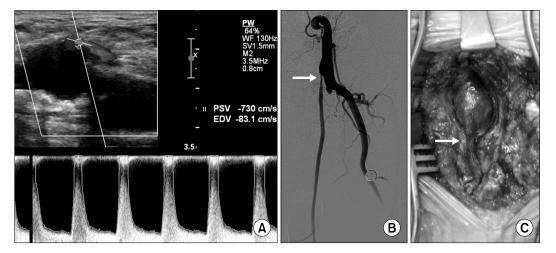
A failing vein graft near the proximal anastomosis of femoro-distal bypass. (A) Duplex ultrasonography showed high (730 cm/sec) peak systolic velocity at the stenotic lesion; (B) tight stenosis (arrow) on digital subtraction angiography; and (C) operative photo of stenotic segment of vein graft close to the proximal anastomosis.
